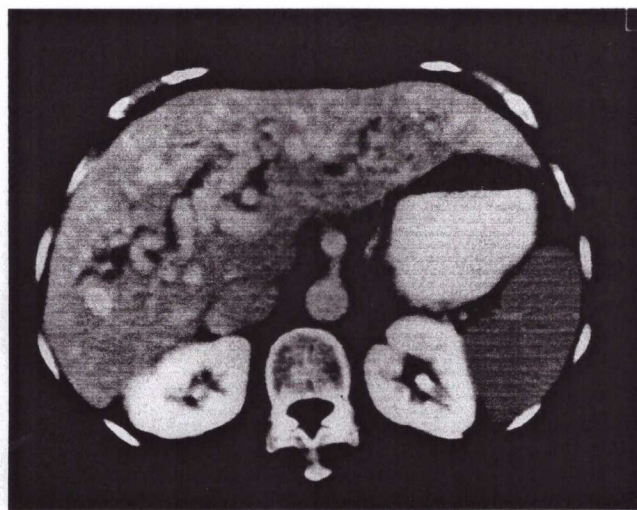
A CT scan showing dilatation of the coeliac trunk and the intrahepatic arteries. Focal dilatation of intrahepatic bile ducts adjacent to enlarged arterial branches is also demonstrated
